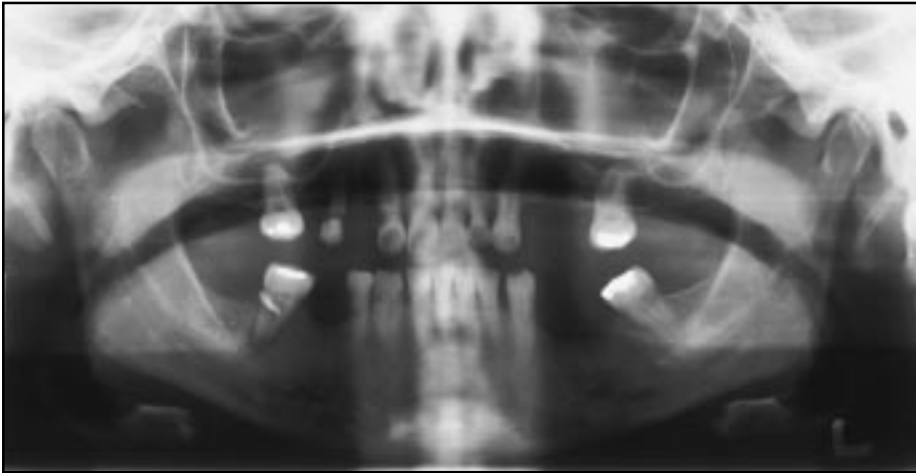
Orthopantomograph highlighting the periapical lesions in 5] and 7].
